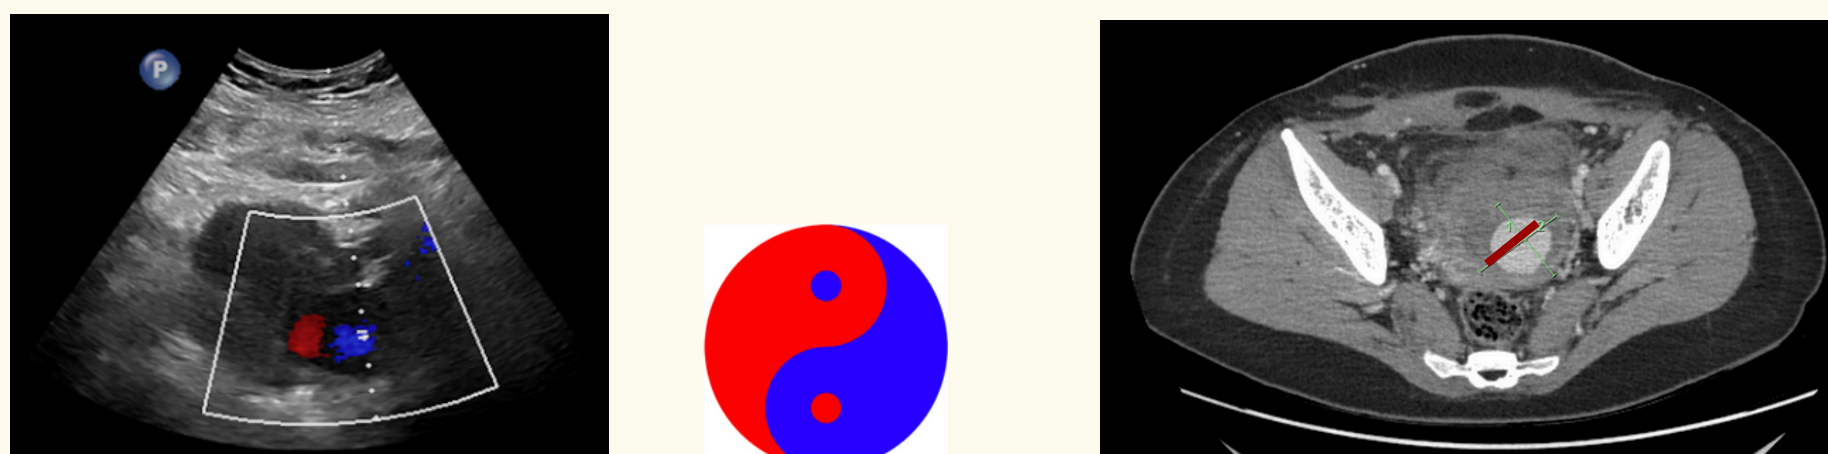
Peri-cervical cystic collection with pulsatile flow and characteristic 'yin-yang' sign on Pelvic US. (figure 2a). Yin-yang sign (figure 2b). Red line demonstrating the false aneurysm with hematoma on CT (figure 2c)
